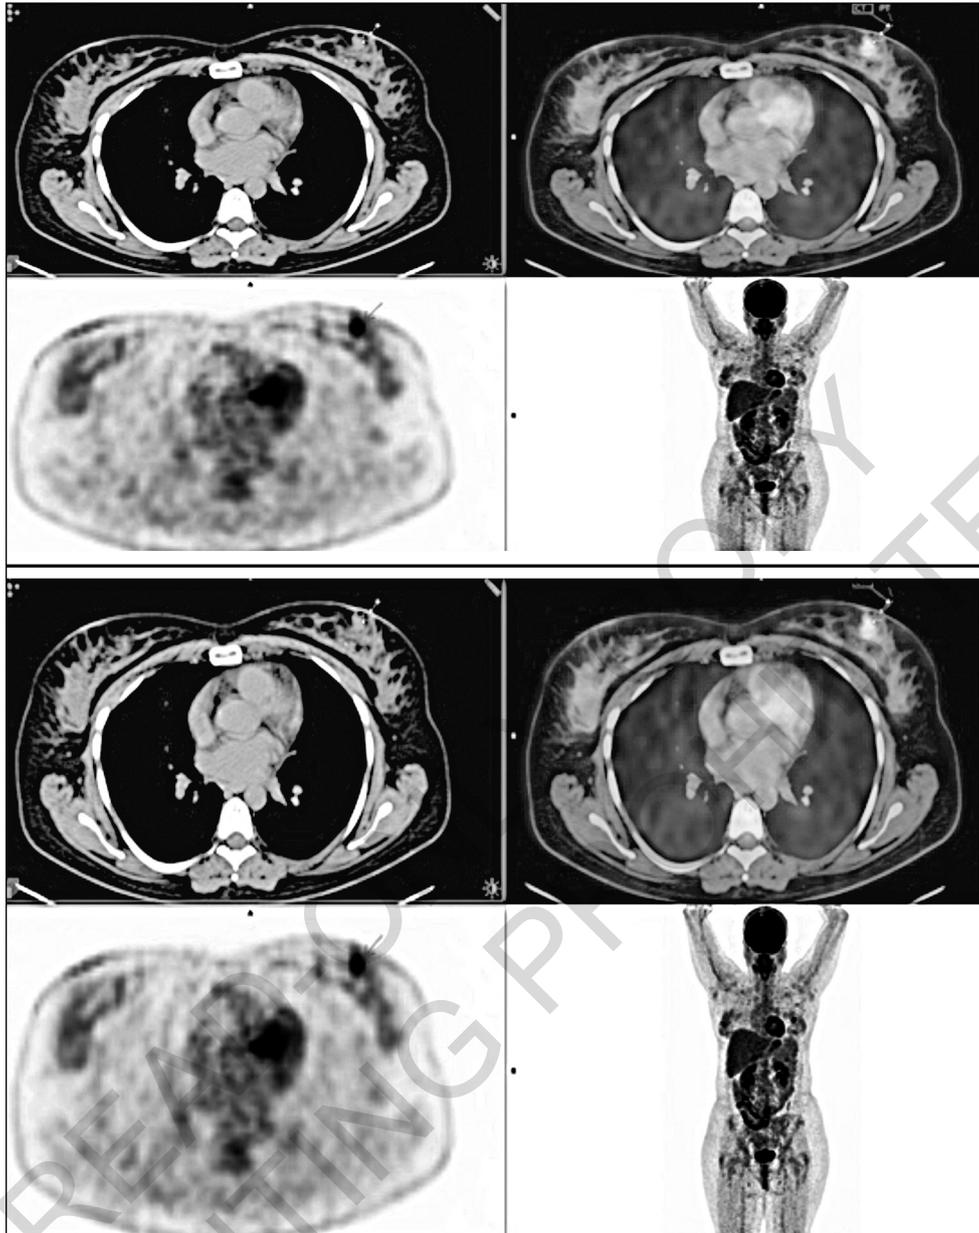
PET-CT IMAGE A 51-year-old woman with a mass of 24 mm in the right breast, with a mass of ER (+), PR (+), Her-2 (-), Grade II Invasive ductal carcinoma, a suspicious lymph node was visible in the right axilla in preoperative staging PET-CT images (arrow). Metastasis was not detected in 5 lymph nodes in sentinel lymph node biopsy. (ER; Estrogen receptor expression status, PR; Progesterone receptor expression status, Her-2; Human Epidermal Growth Factor Receptor 2 status, PET-CT; 18-fluorodeoxyglucose positron emission tomography/computed tomography).
